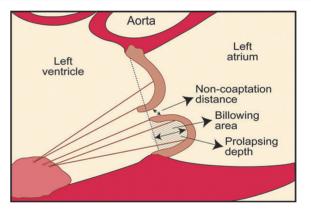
The shaded region, labeled "billowing area," depicts abnormal prolapse of the mitral valve leaflet during systole, causing the "click" sound upon auscultation. (Reproduced with permission from Sénéchal M, et al. Relation of mitral valve morphology and motion to mitral regurgitation severity in patients with mitral valve prolapse. *Cardiovasc Ultrasound*. 2012;10:3.)
